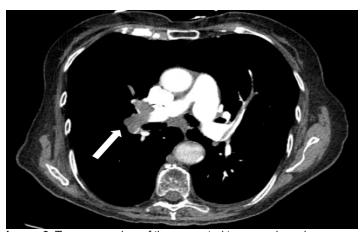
Transverse view of the computed tomography pulmonary angiogram. Image redemonstrates the almost-complete occlusion of the right pulmonary artery trunk with the pulmonary embolus (arrow).
